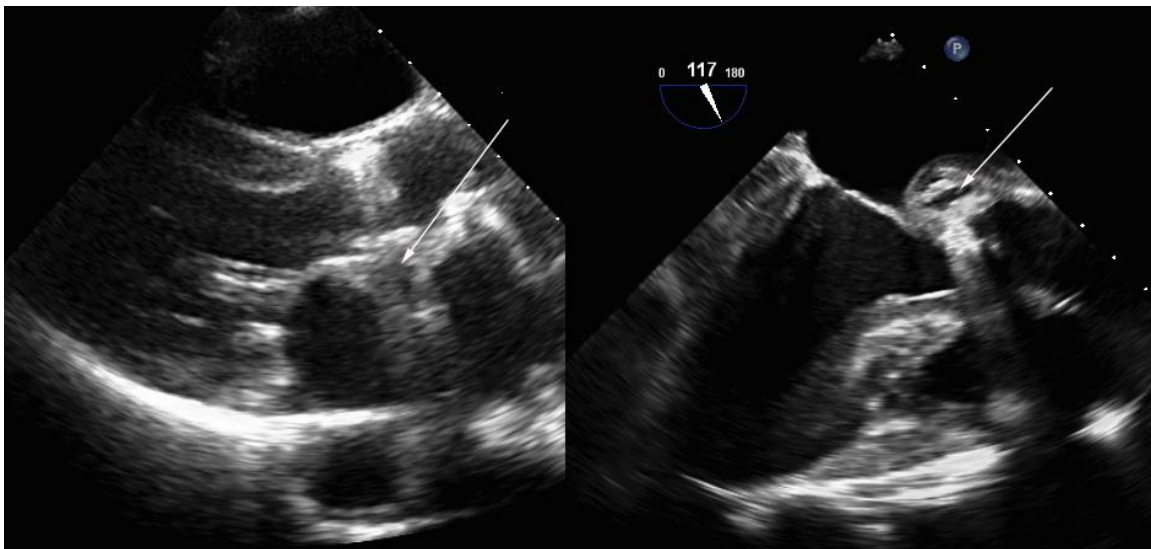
Paravalvular abscess. Transthoracic imaging of a mechanical aortic valve prosthesis from the parasternal long-axis view in a patient presenting with fatigue and elevated white blood cell count (left). Acoustic shadowing from the prosthesis precludes definitive evaluation of the posterior portion of the aortic valve annulus. Subsequent TEE imaging from [View 5] the mid-esophageal long axis view (117°) clearly demonstrates abnormal thickening adjacent to the prosthetic valve with central echolucency concerning for abscess (arrow, right).
